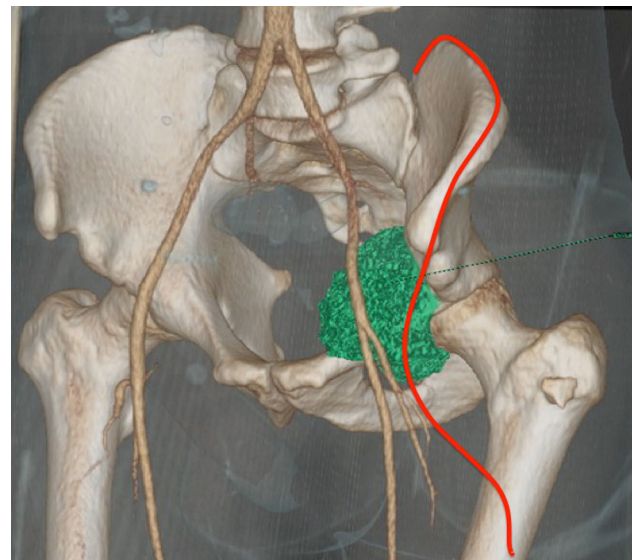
This image shows a three-dimensional CT reconstruction of a Zone II to III sarcoma. The red line shows the standard approach.
